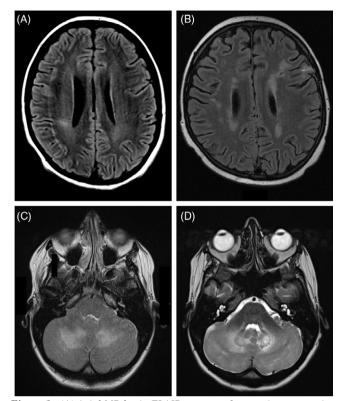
(A) Axial MR brain FLAIR sequence from patient one at time of initial presentation demonstrating bilateral hyperintensities in the centrum semiovale of the parietal lobes. (B) Post-gadolinium axial MR brain FLAIR sequence from patient one 14 months after initial presentation demonstrating progression of bilateral supratentorial white matter hyperintensities and left frontal lobe encephalomalacia at site of previous brain biopsy. (C) T2-weighted MR brain from patient two at time of initial presentation showing bilateral cerebellar hemisphere white matter hyperintensity with local mass effect and relative sparing of the cerebellar peduncles. (D) T2-weighted MR brain from patient two approximately 7 years after initial presentation showing progression of the bilateral cerebellar white matter hyperintensities, now with prominent involvement of the bilateral dentate nuclei.
